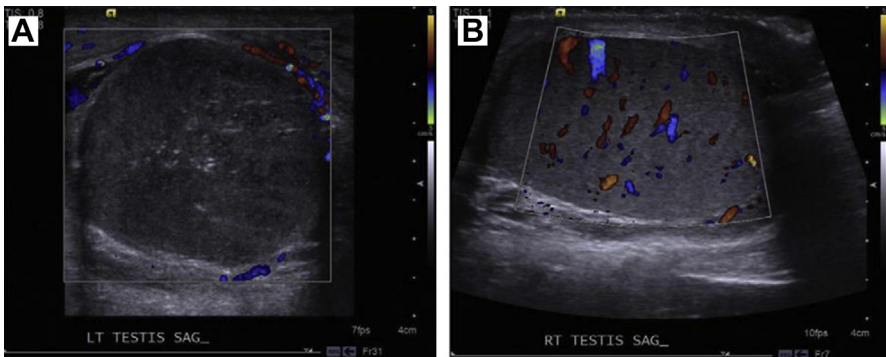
Left-sided testicular torsion as demonstrated by absence of intratesticular Doppler flow on scrotal ultrasound. The right testis demonstrates normal blood flow. (A) Left testicle, which demonstrates no flow on Doppler ultrasound, (B) The normal contralateral testicle with intact bloodflow. (From Wang J-H. Testicular torsion. *Urological Science (Urol Sci)* 2012;23(3):85; with permission.)
